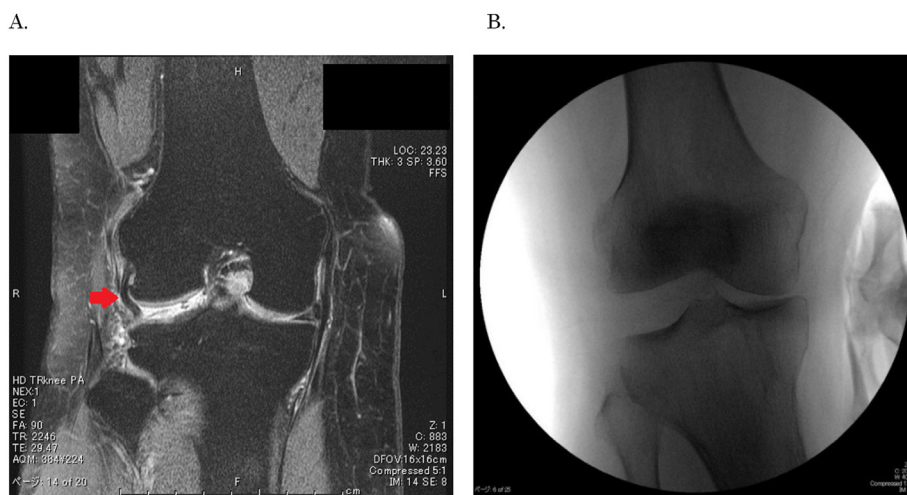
A. MRI showed disruption of FCL. The popliteus tendon was showed the continuity (red arrow). The PFL tear was suspected because of no continuity. We must beware that MRI cannot confirm the PFL tear frequently.
